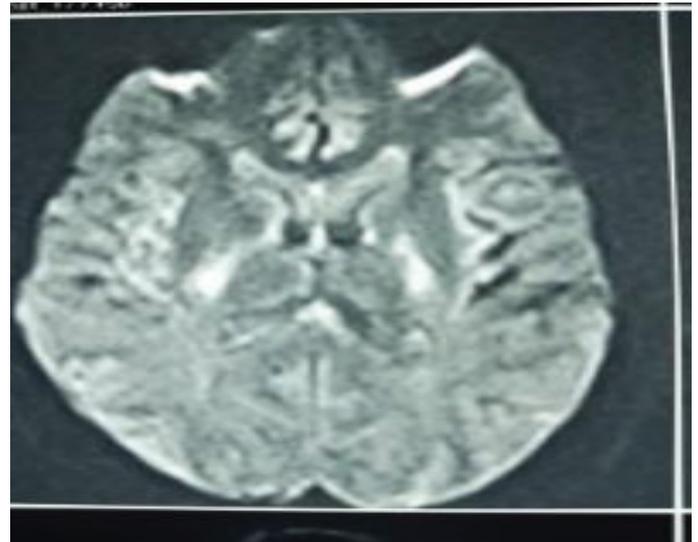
Contrast enhanced brain MRI showing complete resolution of the tuberculoma, only basal cisterns patchy meningeal enhancement is observed.
